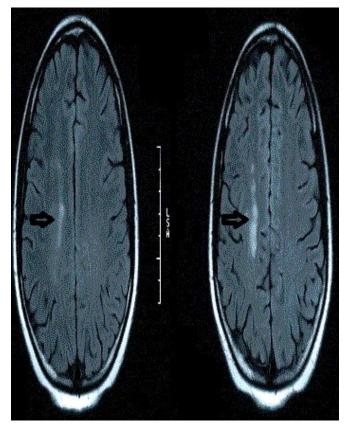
Cerebral MRI: Hyperintensity of the right semi oval center in axial T2 flair (venous infarction).
